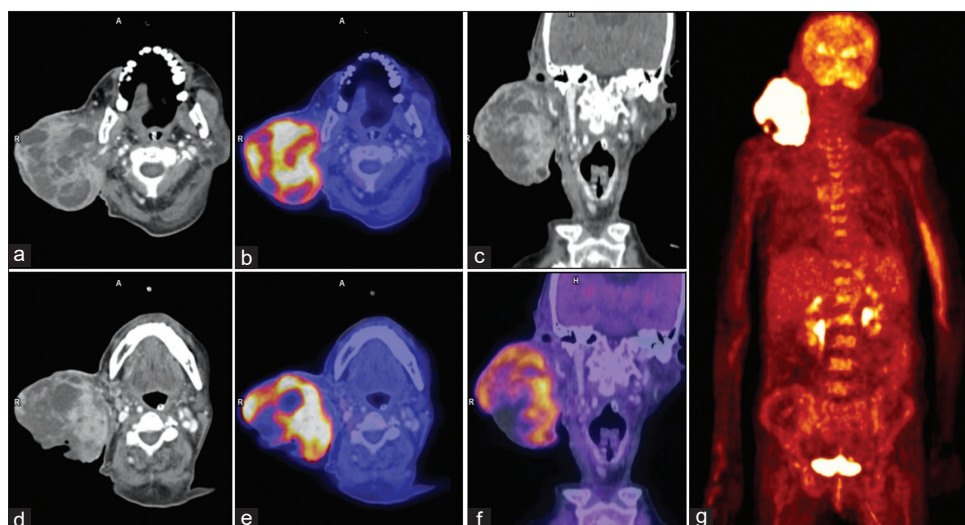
(a and d) Axial contrast-enhanced computed tomography. (b and e) Axial fused ^{18}F -fluorodeoxyglucose positron emission tomography-computed tomography. (c and f) Coronal fused ^{18}F -fluorodeoxyglucose positron emission tomography-computed tomography. (g) Maximum intensity projection image. A heterogeneously fluorodeoxyglucose-avid and heterogeneously enhancing, large, exophytic, solid-cystic mass (~9.0 AP \times 8.4 TR \times 9.77 CC cm, SUVmax: 11.24) is seen in the right parotid space involving the right parotid gland with areas of internal necrosis. Superficially, the lesion is involving the overlying skin and subcutaneous tissue with ulcerative changes. Medially, it is involving the deep lobe of the parotid, the right masticator space, and the right parapharyngeal space and abutting the ipsilateral cortex of the mandible. The right carotid artery and the internal jugular vein were distinctly visualized. Furthermore, faint fluorodeoxyglucose-avid, enhancing right cervical level II lymph nodes are noted (1.3 cm \times 1 cm, SUVmax: 4.35). Maximum intensity projection image reveals the primary mass in the right parotid region, with no other metabolically active lesion elsewhere in the body
